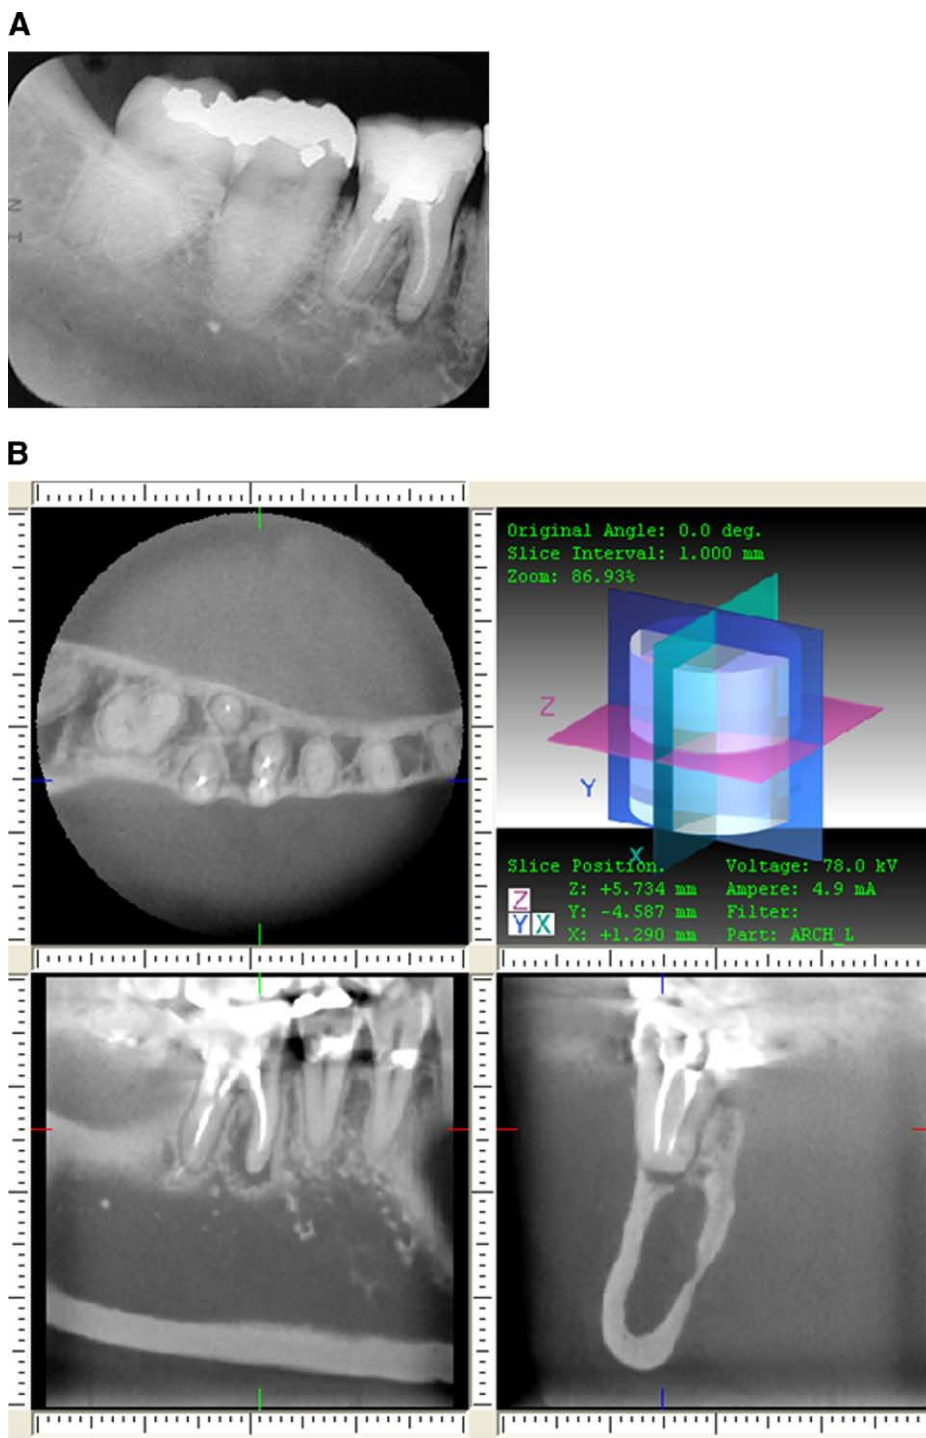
A, Images obtained by conventional periapical radiograph. B, Images obtained by 3D volumetric tomography , not indicates the fracture in the tomography.
